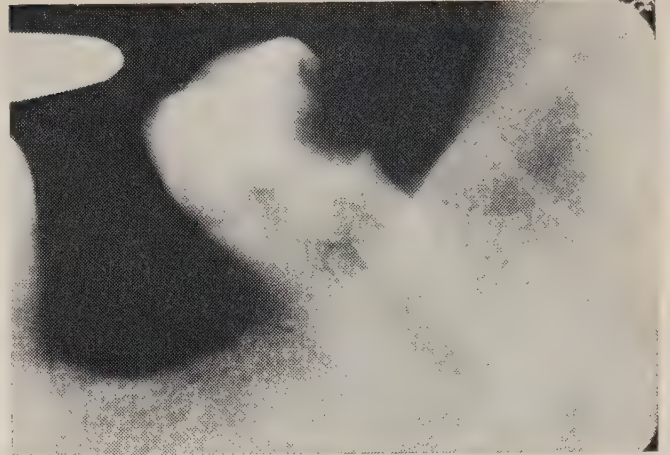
Periapical radiograph of lower left molar region taken on March 2, 1966, at first admission.
